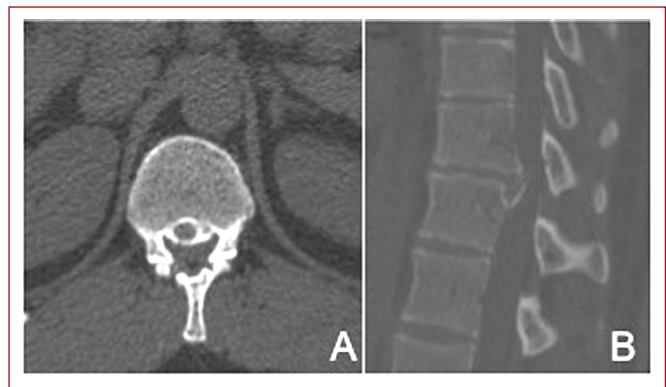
a) Axial and b) sagittal CT demonstrating calcified thoracic disc herniation.
